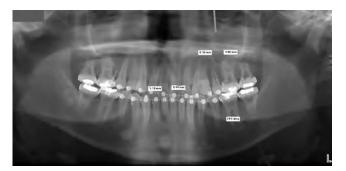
Panoramic radiography incorporated in the V-Ceph Image software (Osstem, Seoul, Korea). Source: Park et al.<sup>1</sup>, 2018.
